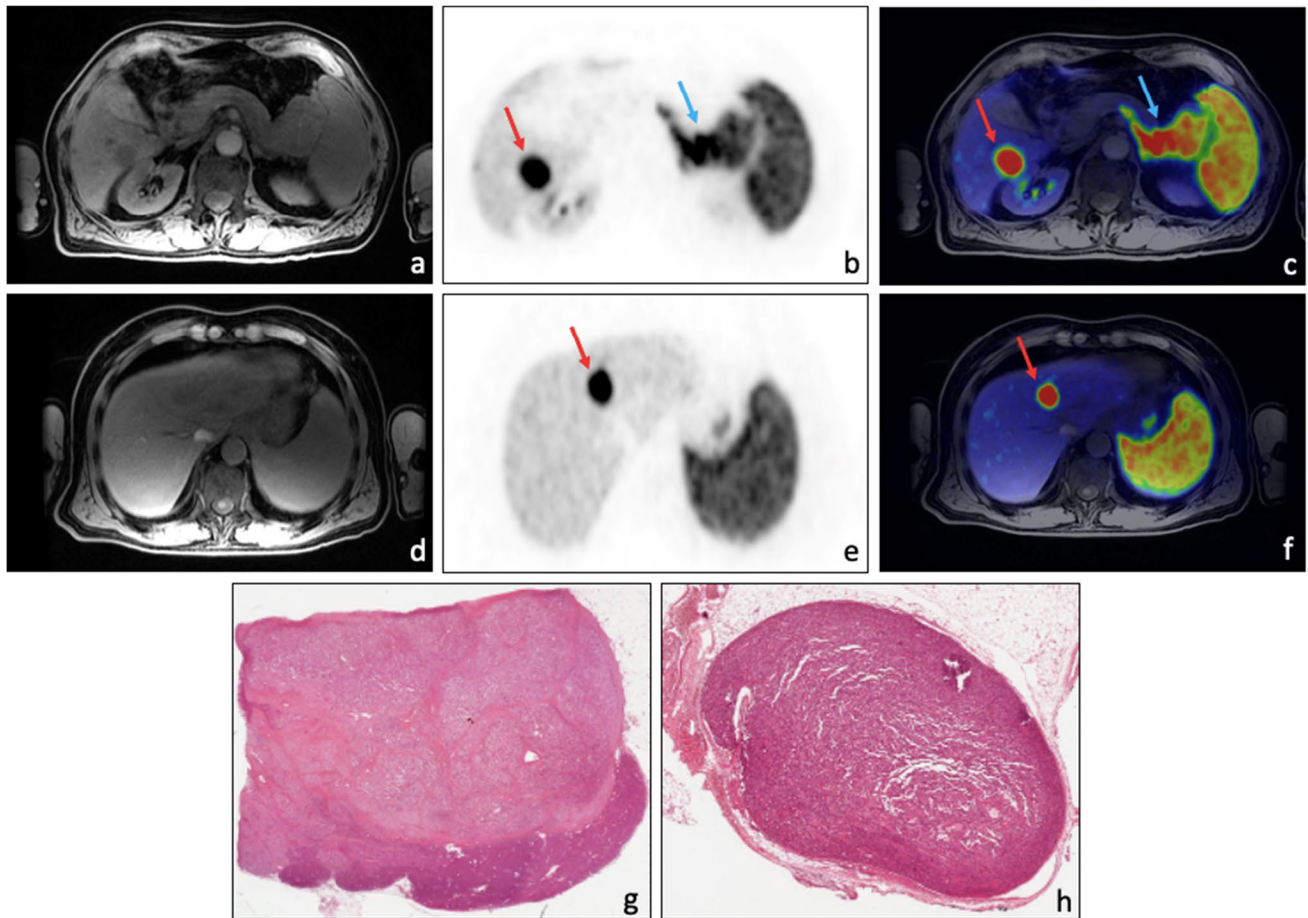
^{68}Ga -DOTATOC PET/MRI performed for PanNET staging. A 60-year-old patient underwent ^{68}Ga -DOTATOC PET/MRI. ^{68}Ga -DOTATOC PET/MRI showed intense uptake in correspondence of the pancreatic tail (a: axial Lava Flex MRI; b: axial ^{68}Ga -DOTATOC PET, cyan blue arrow; c: axial ^{68}Ga -DOTATOC PET/MRI, cyan blue arrow) and two pathological uptakes in correspondence of the VI (b
